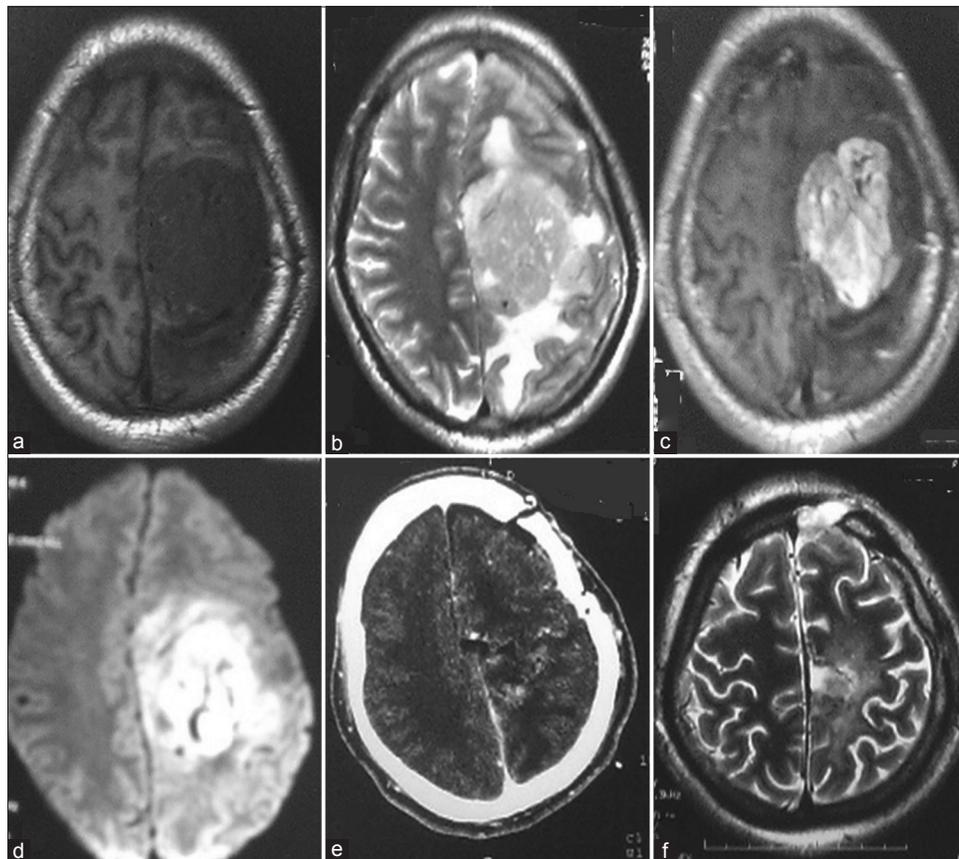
(a) T1-weighted magnetic resonance imaging showing hypointense lesion in frontoparietal convexity region, (b) T2-weighted magnetic resonance imaging: Hyperintense with multiple flow voids and adjacent edema, (c) well-enhanced on contrast, (d) diffusion-weighted image suggestive of restriction in lesion. (e and f) Postoperative chemotherapy (immediate postoperative) and magnetic resonance imaging (after 3 months) suggestive of complete excision after surgery
